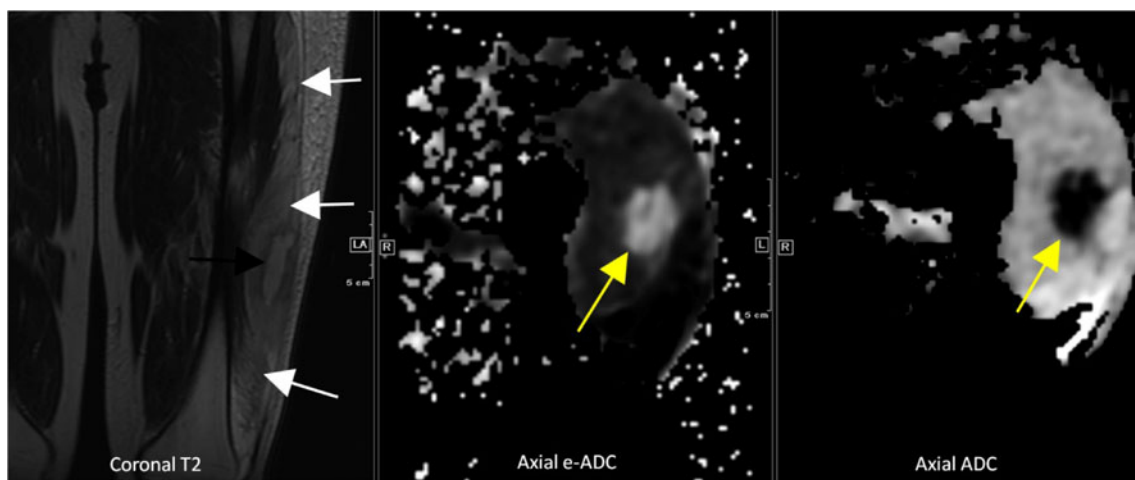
(Case 3): Coronal T2-weighted MR image through the thigh demonstrates diffuse/extensive edema in the vastus lateralis (*white arrows*) along with an elongated intramuscular fluid collection (*black arrow*). The fluid collection is e-ADC hyperintense (*yellow arrow*)
